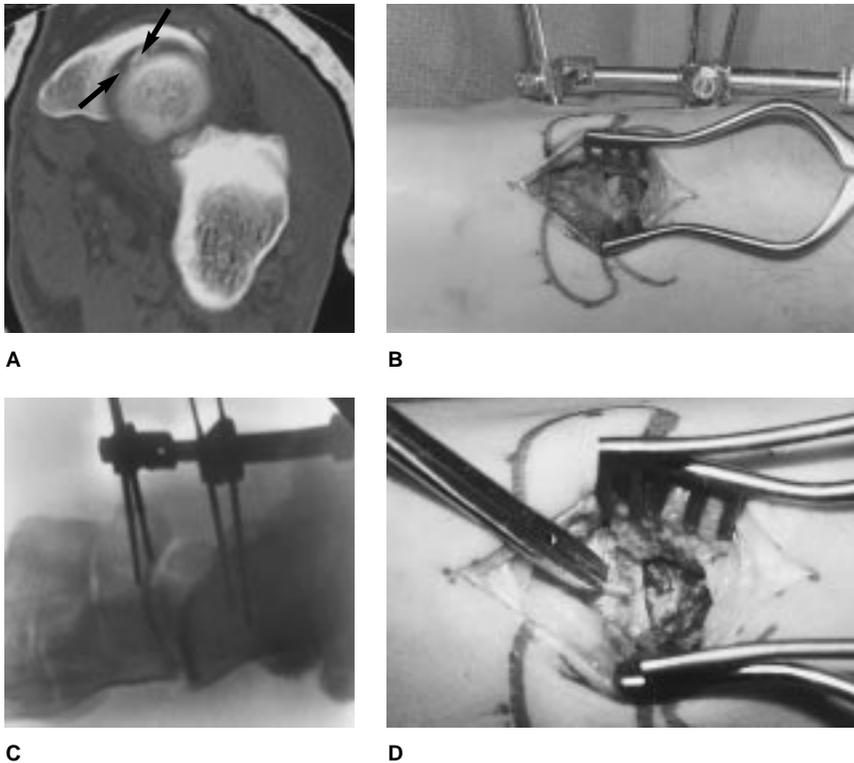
A, Transverse CT scan of a foot immediately after closed reduction of a medial subtalar dislocation. Arrows indicate osteochondral fragments in the talonavicular joint. Operative removal of the fragments was recommended. B, Intraoperative photograph with the talonavicular joint exposed. A small external distractor was used to gain access to the joint. C, Intraoperative fluoroscopic radiograph demonstrates the use of the small distractor to aid exploration of the talonavicular joint. D, Close-up photograph shows removal of talonavicular joint fragments. In this case, as is generally true with medial subtalar joint dislocations, the osteochondral fragments came from the dorsal talus rather than the relatively harder navicular bone.
